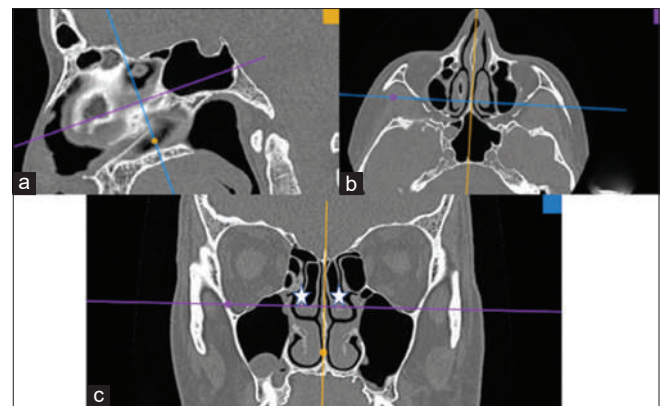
CT images brought to orthogonal plane in sagittal (a), axial (b) and coronal (c) plans. Asterisk show bilateral pneumatized middle turbinate, CT: Computed tomography
